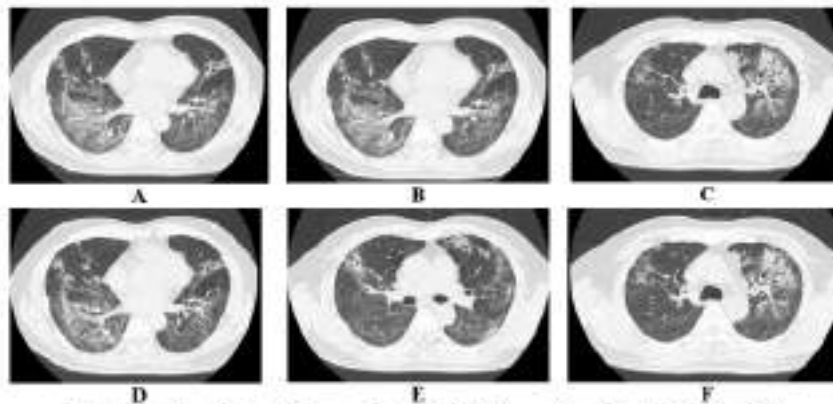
Serial of Chest CT Scan, 7 April 2020 (Illness Day 35, Hospital Day 29)
